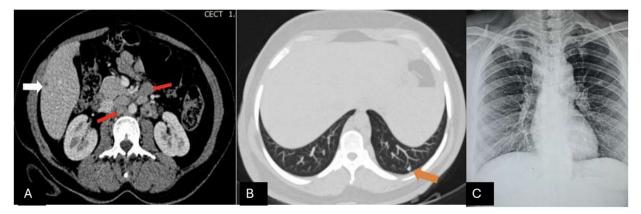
Chest radiograph in abdominal TB (EPTB) (A): Abdominal CECT (axial section) shows multiple enlarged, conglomerated lymph nodes in mesentery and retroperitoneum (red arrows). A hypodense granuloma (white arrow) is also seen in liver. (B) Lung window (Maximum Intensity Projection) through the upper abdomen shows few centrilobular nodules (orange arrow). (C): Chest radiograph PA view shows right paratracheal stripe widening (blue arrow) suggestive of lymphadenopathy. Laboratory investigations for TB were equivocal. ATT was started based on clinico-radiological diagnosis of Disseminated TB; and the patient had no complaints after 6 months.
